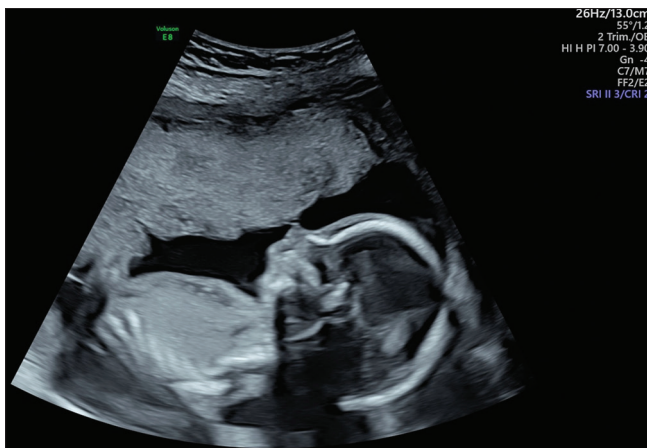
Mid-trimester ultrasound: glossoptosis as the tongue is displaced posteriorly
